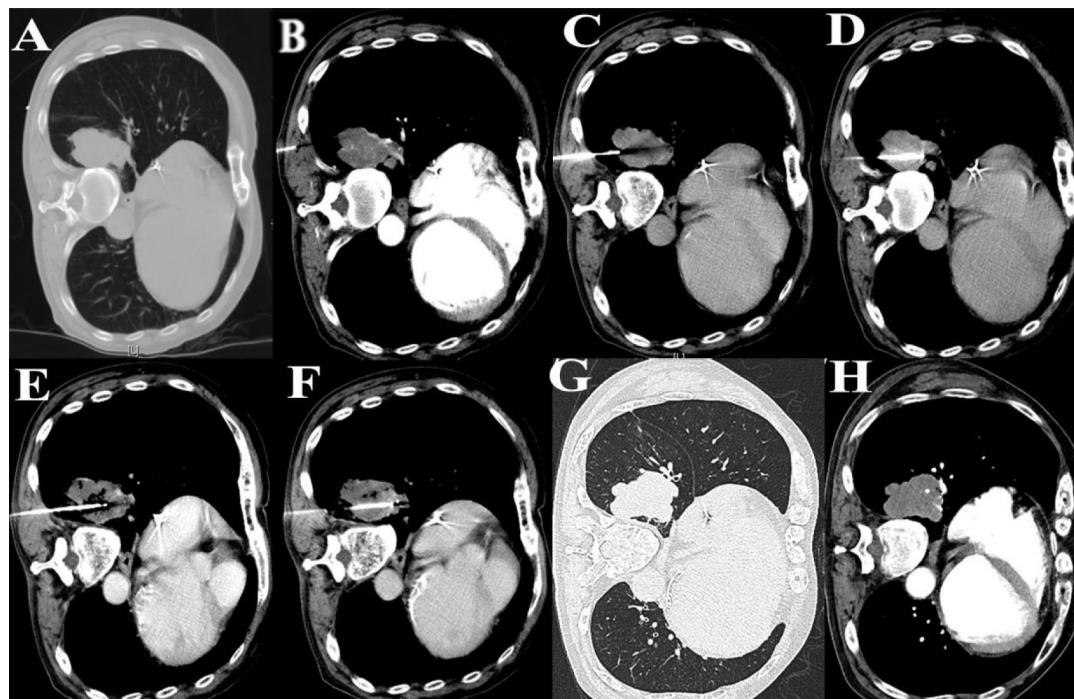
Microwave ablation procedure in primary cancer. Plain CT scan was performed before puncture procedure to map the tumor size and location A: For large mass, contrast-enhanced CT clearly showed vessels in the tumor to avoid bleeding caused by puncture damage. B: The step-by-step puncture procedure is shown in (C,D). Repeat ablation was performed to ensure complete ablation (E,F). Plain CT scan was performed after ablation procedure to exclude aemothorax and bleeding (G,H).
